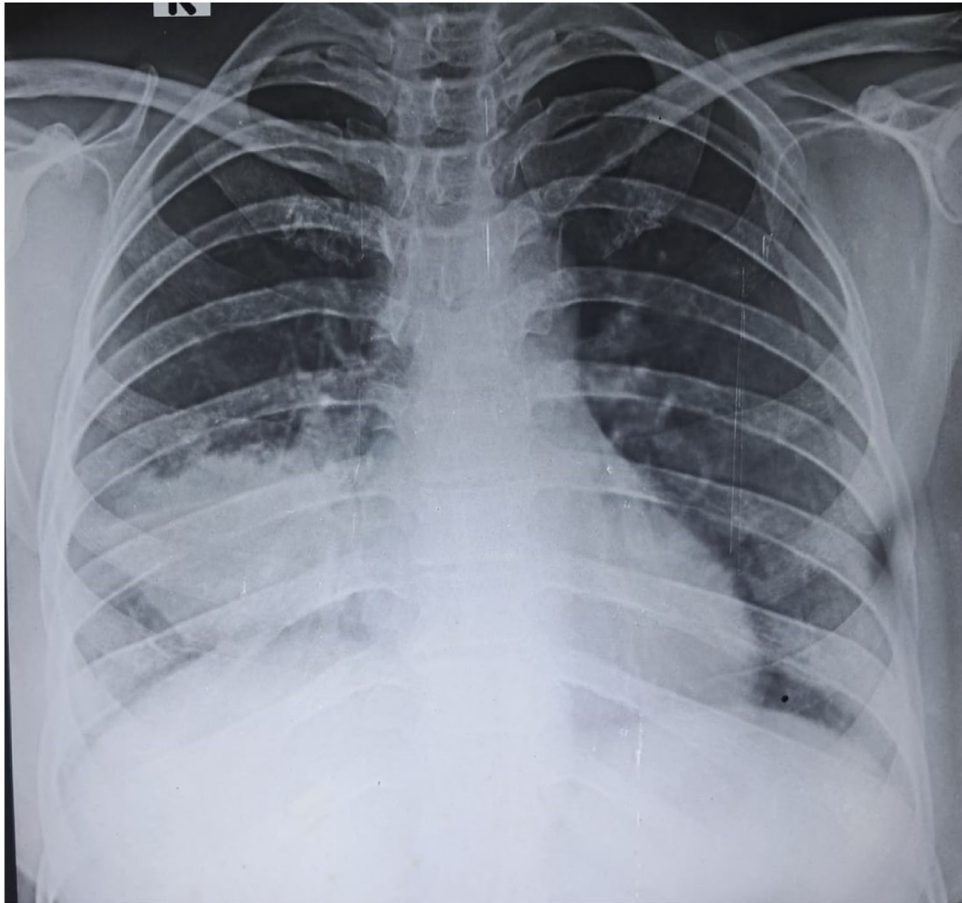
Chest x-ray P/A view showing cavitation at the right lower lung field.
